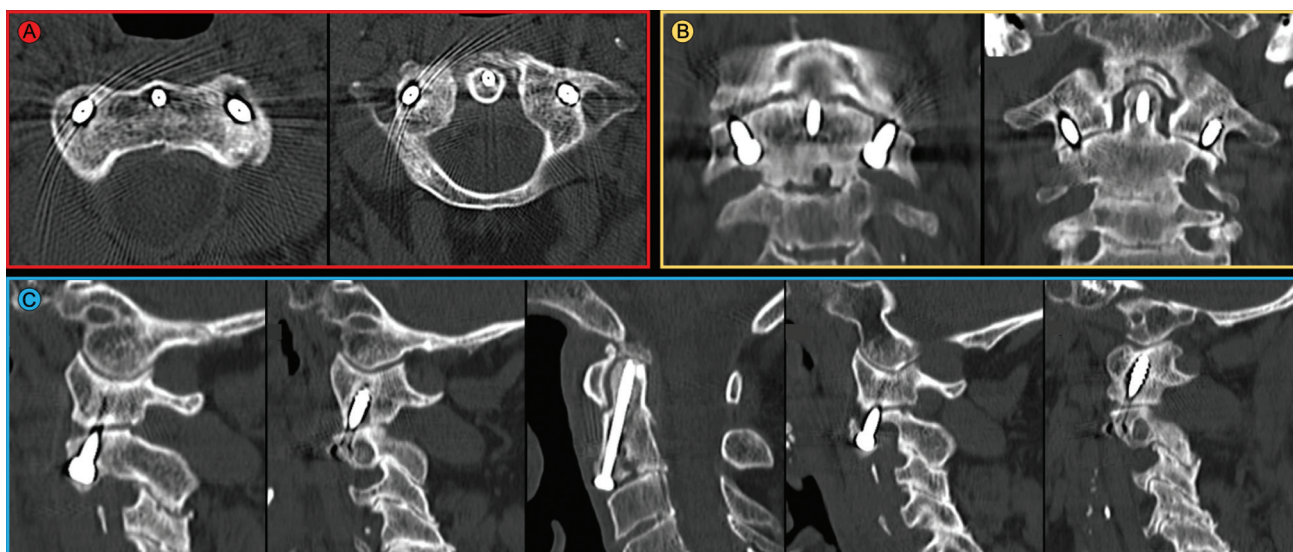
Computed tomography scan at 12 months postoperatively showing fracture consolidation and correct alignment of the screws on the axial (A), coronal (B) and sagittal (C) planes. A slight degree of osteolysis around the transarticular screws can be observed, as expected, because there is no arthrodesis, as mentioned in the discussion.
